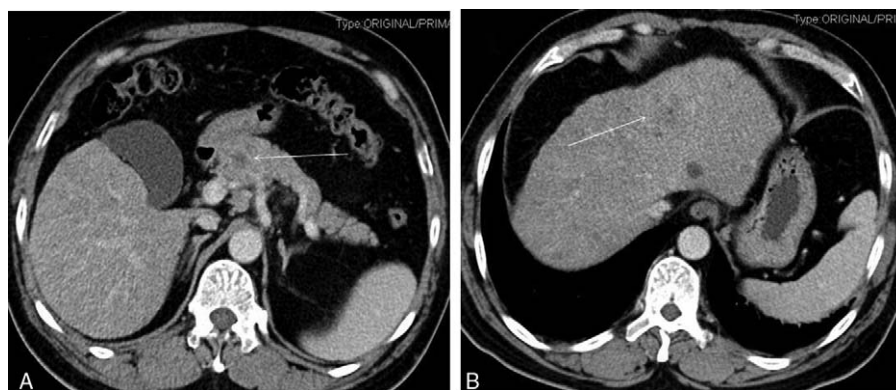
CT scan suggested a heterogeneous enhanced mass in the pancreatic head (A: white arrow) and an unobvious mass in the left of the liver (B: white arrow). CT=computerized tomographic scanning.
